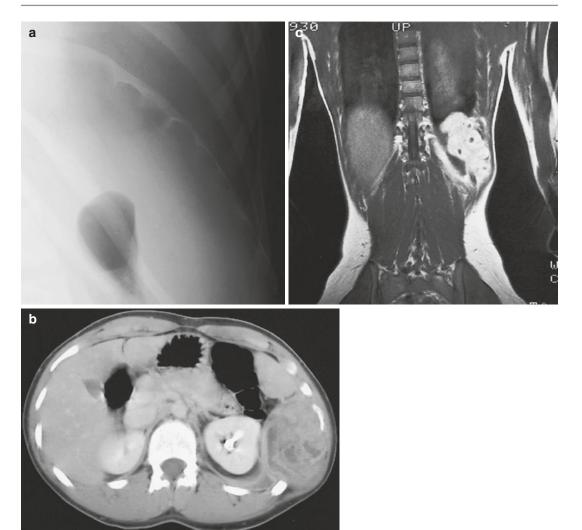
(a–c) Schwannoma of the chest wall in a 16-year-old boy: (a) plain radiograph of the rib cage shows irregular scalloping (notching) of the inferior border of the left tenth rib and widening of the intercostal space. (b) CT scan after iodinated contrast injection shows
